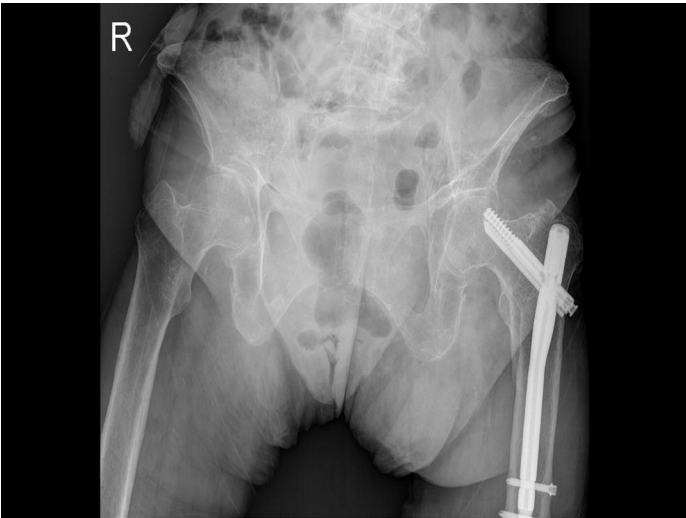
Postoperative 7th year AP radiography
